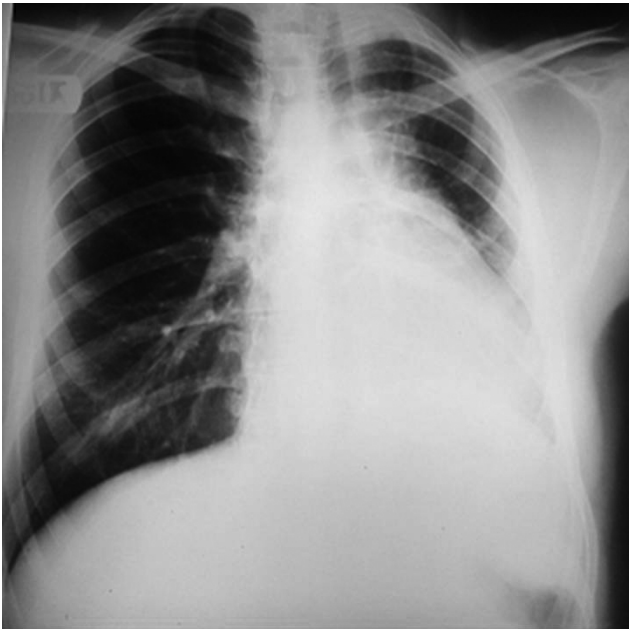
Chest X-ray (posteroanterior view) shows leftward shifting of the trachea and decreased rib distances in the left side. Compensatory hyperinflation in contralateral hemithorax was also noted.
